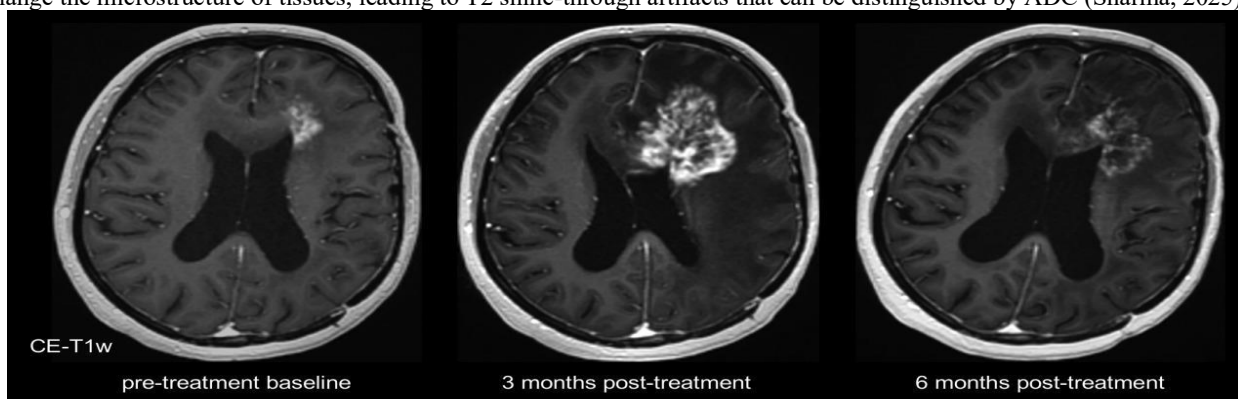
Serial contrast-enhanced (CE) T1-weighted (T1w) imaging showing increase 3 months and spontaneous decrease 6 months after combined radiotherapy
